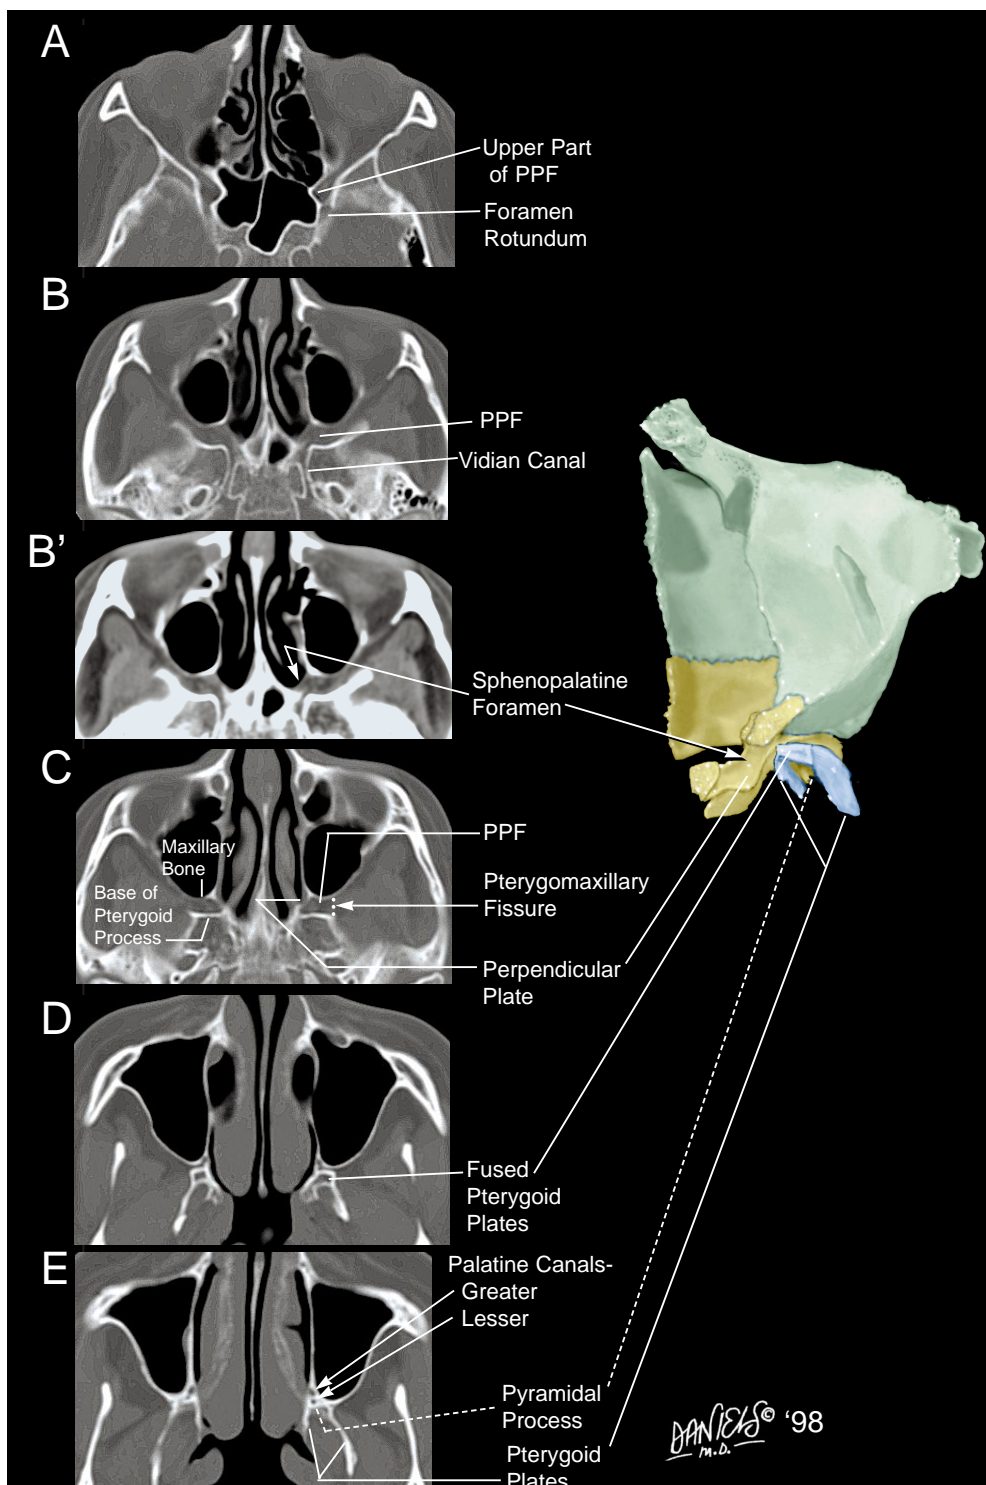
Axial CT scans show osseous anatomy of the structures marginating the PPF, obtained superiorly to inferiorly, referenced to Figure 5C.
